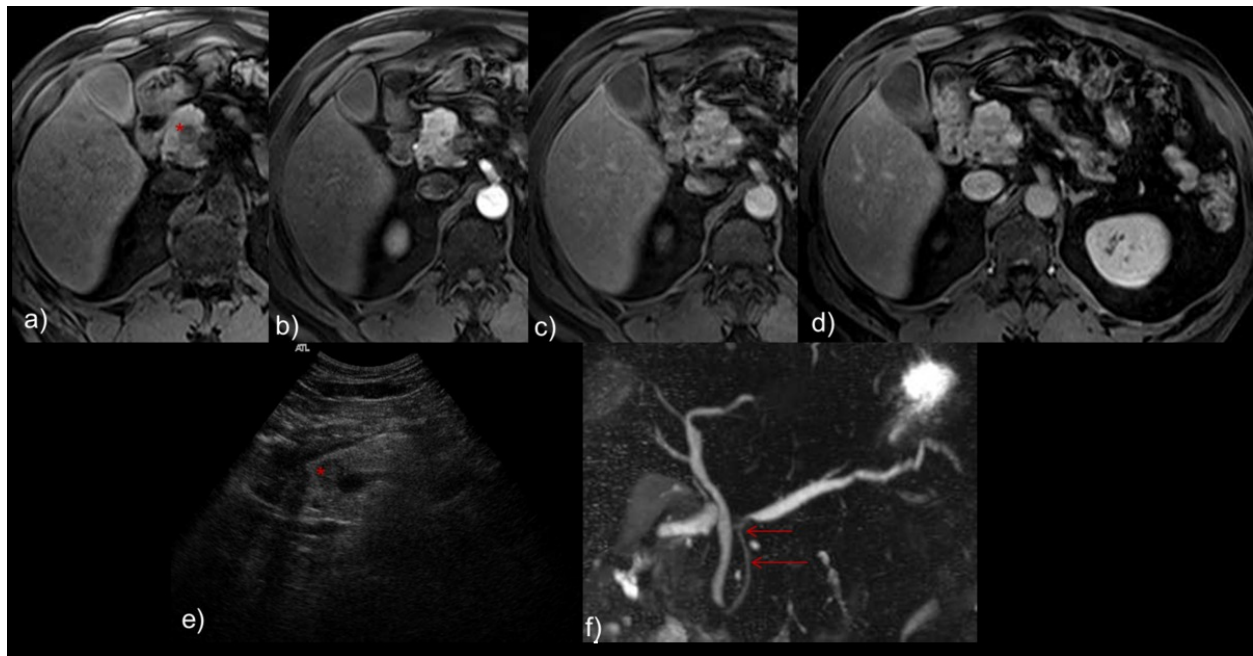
Axial T1 3D fat-saturation images a) b) c) d), transversal ultrasound image e), coronal oblique thick slab MRCP image f) - Patient with a hypoechogenic peri-centimetric nodule at the pancreatic head. This nodule was not observed at CT and in MR the nodule was hypointense in T1 enhancing similarly to the remaining pancreatic head, with absence of clear demarcation between the focal nodule and the parenchyma. DWI (not shown) demonstrated restricted diffusion. At MRCP a regular and smooth narrowing of the main pancreatic duct at the pancreatic duct - duct penetrating sign (arrows) is seen suggesting the diagnosis of focal pancreatitis.
